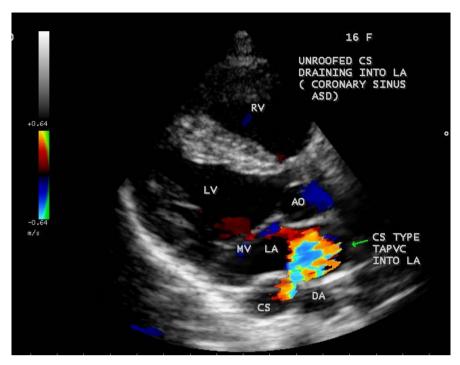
Parasternal long axis view showing the drainage of unroofed coronary sinus into the left atrium, constituting a right-to-left shunt-coronary sinus ASD (atrial septal defect) with total anomalous pulmonary venous connection (TAPVC).
